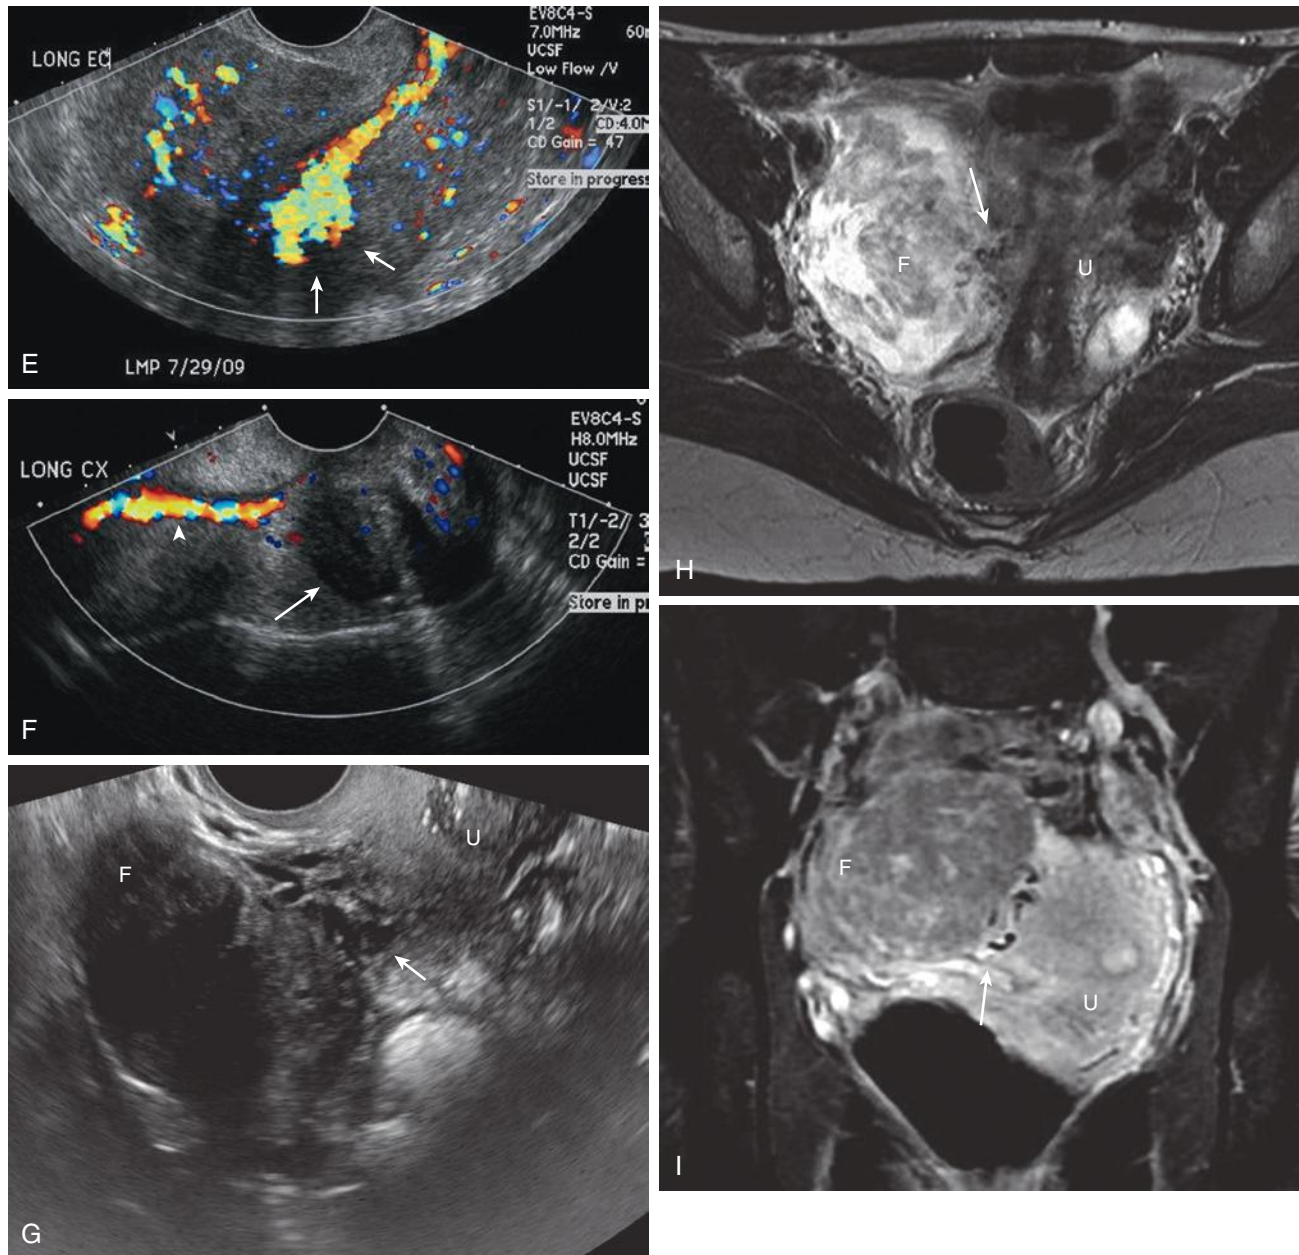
cont'd E, Transvaginal sagittal view of the uterus demonstrating a hypervascular stalk (*arrows*) arising from the posterior wall of the uterus and extending through the endometrial canal into the endocervical canal (right side of image). F, The hypervascular stalk (*arrowhead*) is connected to a well-demarcated, rounded, hypoechoic mass (*arrow*) with posterior shadowing that splays the endocervical canal, consistent with a prolapsed leiomyoma. Without the color Doppler demonstration of the vascular stalk, these findings could mimic a cervical leiomyoma. G, Transvaginal transverse view of a hypoechoic, slightly lobulated shadowing pedunculated leiomyoma (F) in right adnexa. Uterus (U) is medial to the leiomyoma. Tubular anechoic structures (*arrow*) between the leiomyoma and the uterus represent vessels in the bridging pedicle. The bridging vascular pedicle sign is often better seen on magnetic resonance imaging (MRI) and has been reported to be present in more than 70% of pedunculated leiomyomas. H, Axial T2-weighted (T2W) MRI image of the right pedunculated leiomyoma (F), demonstrating black (T2 dark) squiggly flow voids of vessels within the pedicle (*arrow*). U, uterus. I, Coronal T2W with fat saturation MRI image demonstrating the pedunculated right leiomyoma (F), medially displaced uterus (U), and T2 dark flow voids (*arrow*) in the vascular pedicle.
